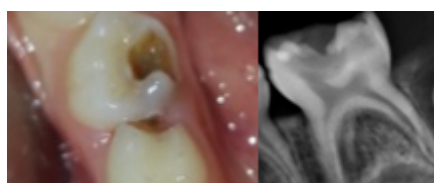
Clinical and radiographical examination of included non vital primary molar.
